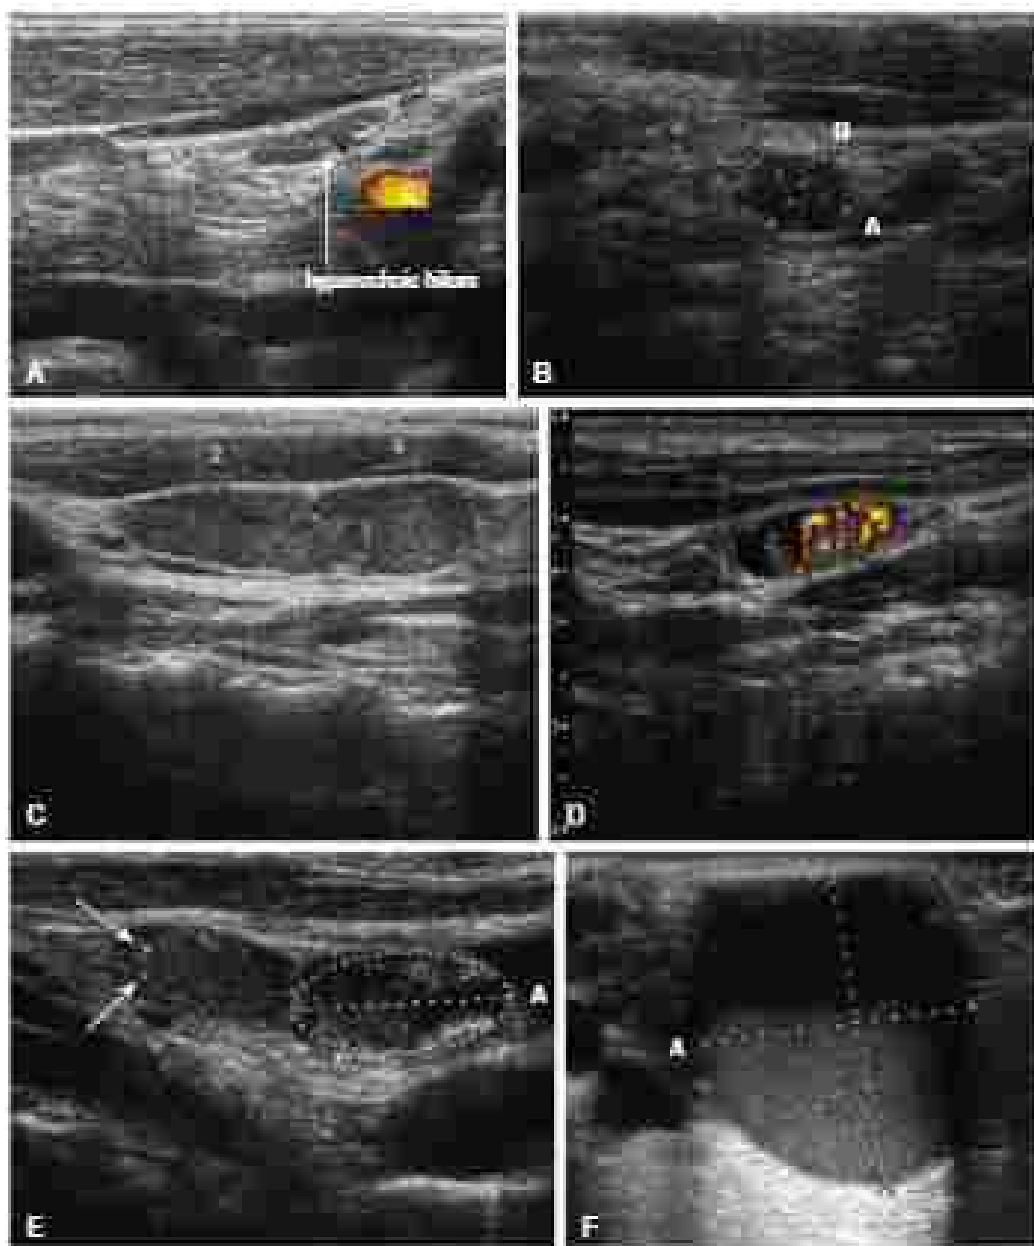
(A) Large lymph node shows hyperplastic germ. (B) Malignant nodules and hyperplastic lymph node. (C) Malignant lymph node with loss of hyperplastic germinal center. (D) Malignant lymph node with peripheral and central vascularization. (E) Malignant lymph node with hyperplastic germinal center. (F) Malignant lymph node with cystic degeneration. (from: Ichiyasu S, Cavali F, Ruz M, et al. Ultrastructural features of malignancy in cervical lymph nodes in patients followed up by ultrasonically guided core needle biopsy. *Chin J Cancer Res*. 2001;97:280-294)
